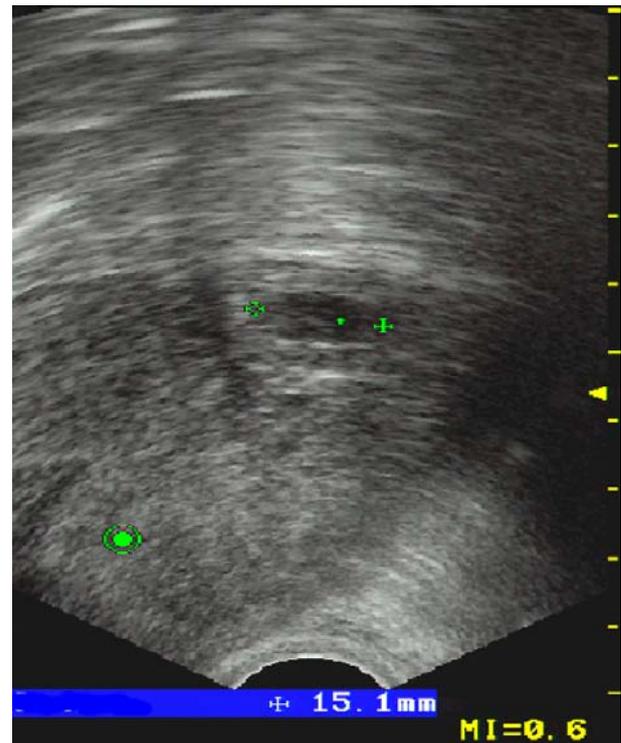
Sonographic picture of an ectopic interstitial pregnancy
